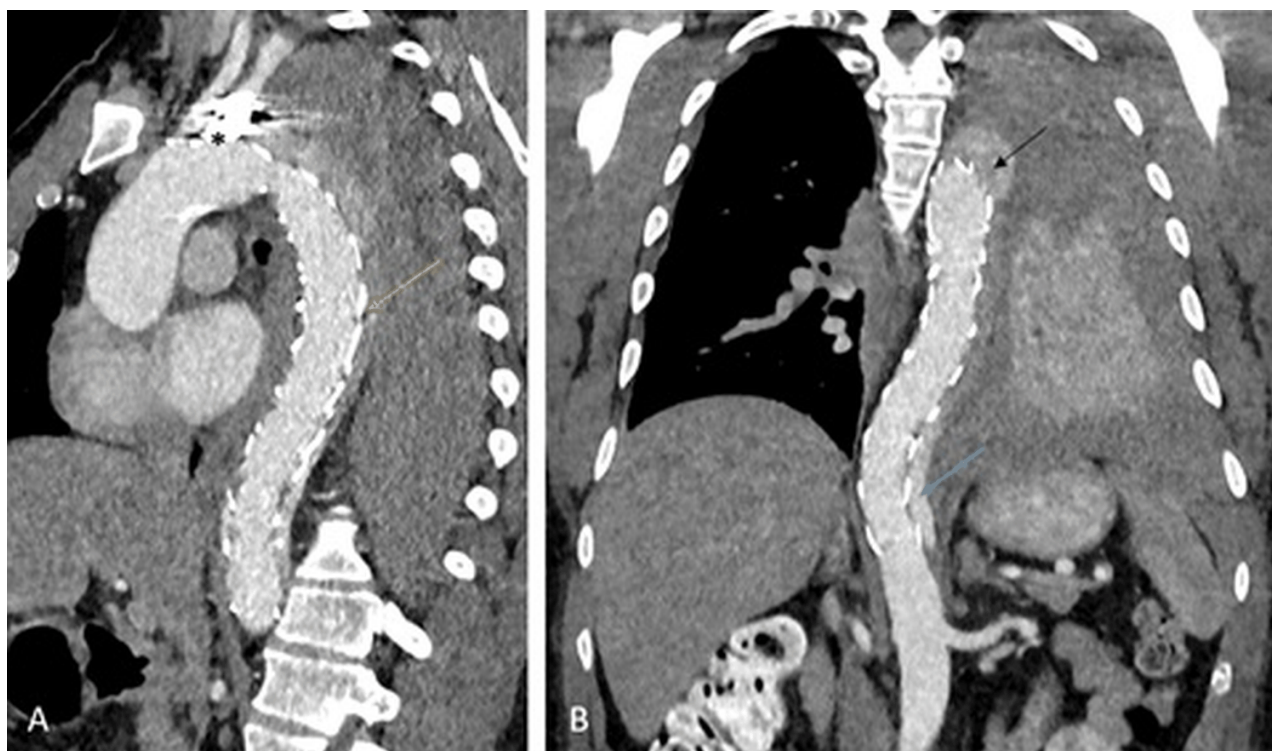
CT aortography after TEVAR.
